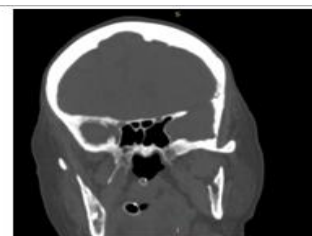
Coronal CT shows type III optic nerve at left side (arrow) where more than 50% of the nerve is surrounded by air
